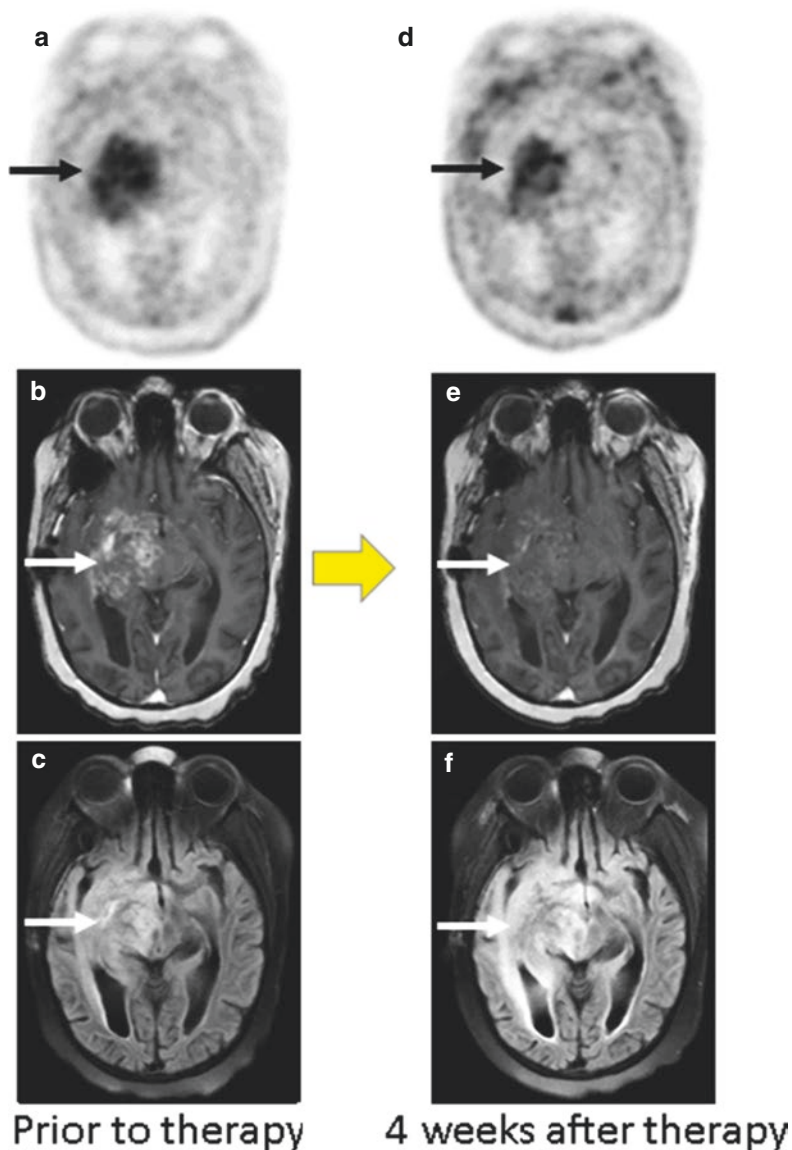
FDOPA-PET/MR imaging in an 8-year-old girl with small cell glioma before and after bevacizumab therapy. The initial FDOPA-PET image (a) demonstrates increased uptake throughout the mass (arrow) involving the right frontal and temporal lobe as well as the brainstem. This mass shows heterogeneous enhancement on the post-contrast MR image (b) and FLAIR signal hyperintensity (c). After 4 weeks of bevacizumab, the uptake of FDOPA decreased slightly but there is persistent activity (d). The contrast enhancement has nearly completely resolved (e), but the FLAIR signal abnormality is unchanged (f). The persistent FDOPA uptake suggests poor response to therapy, and the patient subsequently had progressive disease. This case was part of a recent publication examining the potential of FDOPA-PET/MRI to predict response to bevacizumab early in the course of therapy [108]. (a) pre-bevacizumab FDOPA-PET; (b) pre-bevacizumab post-contrast T1; (c) pre-bevacizumab FLAIR; (d) post-bevacizumab FDOPA-PET; (e) post-bevacizumab post-contrast T1; (f) post-bevacizumab FLAIR
